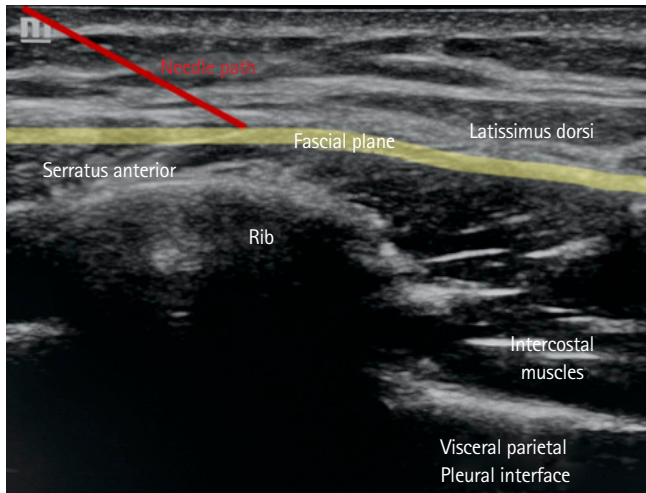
Ultrasound images in the transverse view at the midaxillary line. The target is the fascial plane (yellow) in between the latissimus dorsi muscle and serratus anterior muscle. Needle path (red) should be at a 30° to 60° angle from the skin. For orientation purposes the intercostal muscles, rib, and visceral parietal pleural interfaces have been noted in the figure.
